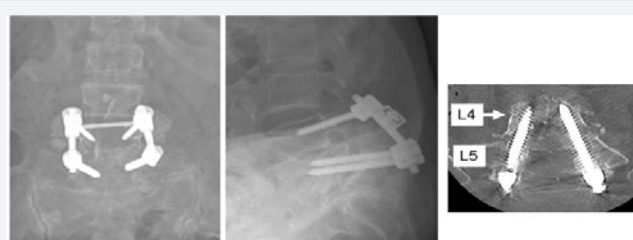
Postoperative radiographs showing the successful transdiscal screwing. The L3 pedicle screws were normally placed as usual, L5 screws were placed through the L5 pedicles, and through the superior endplate of L5, through the inferior endplate of the L4 to terminate in L4 body.
